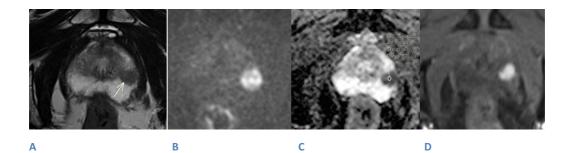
Example of PIRADS 5 lesion in PZ (white arrow on A) –Very high likelihood of being a clinically significant cancer. DWI is a dominant sequence in PZ lesions and shows focal marked hyper-intensity on high B-value image (B) with corresponding focal markedly hypo intense lesion on ADC (C) with low signal area on T2WI image (A) and early contrast enhancement on DCE (D)
